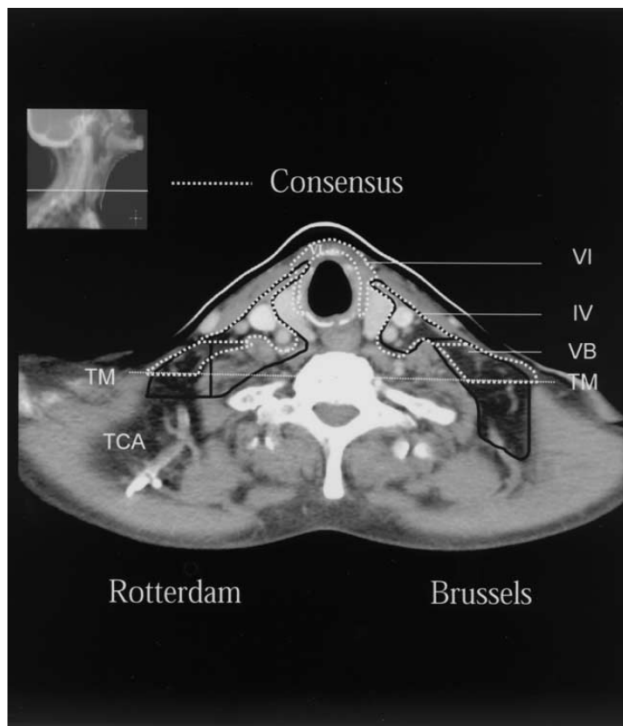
Axial CT slice, taken in region of lower neck (level of supraclavicular fossa) with nodal Levels IV, V, VI (solid black lines), contoured according to “simplified” Rotterdam (right neck) (2) and Brussels (left neck) (3) delineation protocols. Stipulated white lines (both necks) demarcate contours of same levels and sublevels, when defined by Rotterdam/Brussels consensus proposal (see also Fig. 7). Virtual horizontal line between anteromedial heads of trapezius muscles (TM) demarcates posterior boundary of Level VB (see text for details).
